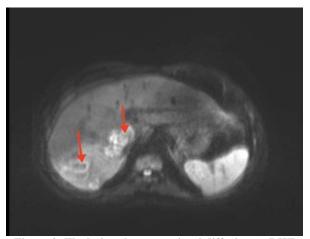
The lesion shows restricted diffusion on DWI images
